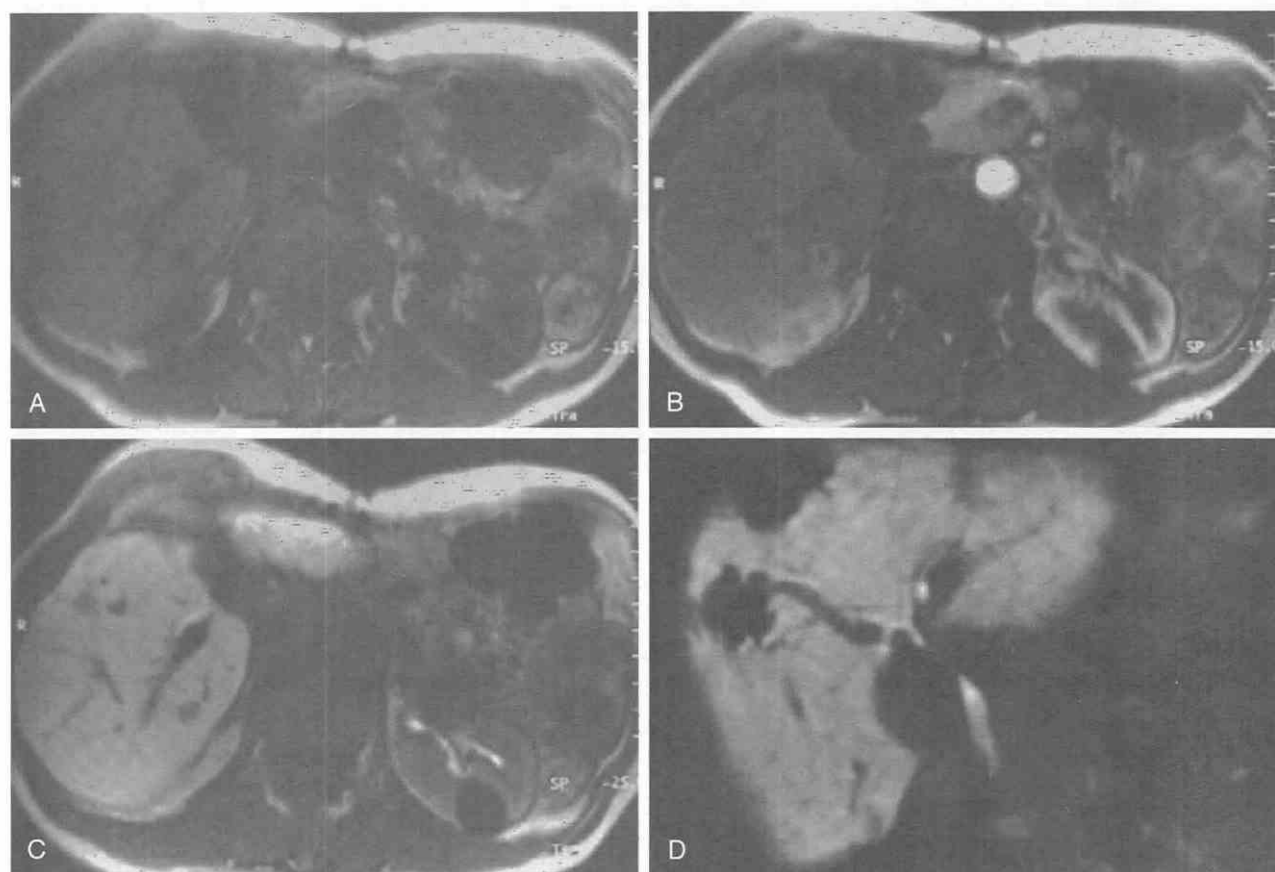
Metastases. *A*, Unenhanced T1-weighted MR image demonstrates few low-signal-intensity lesions. *B*, T1-weighted MR image after gadolinium (Gd-EOB-DTPA) administration in the arterial phase shows ring enhancement of the lesions. *C* and *D*, The lesions were much more conspicuous on delayed imaging.
